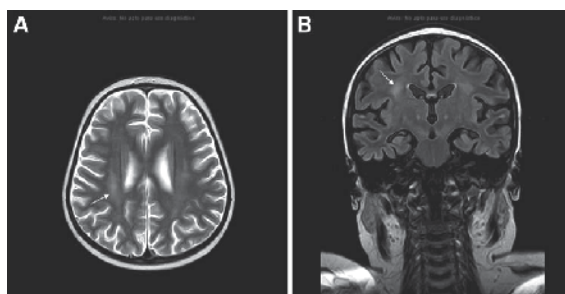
MR imaging findings six weeks after an episode of subacute encephalopathy by MTX. White arrows in Axial T2 (A) and coronal FLAIR (B) sequences show deep and periventricular white matter hyperintensity, especially in the right hemisphere (Vagace et al., 2011).
